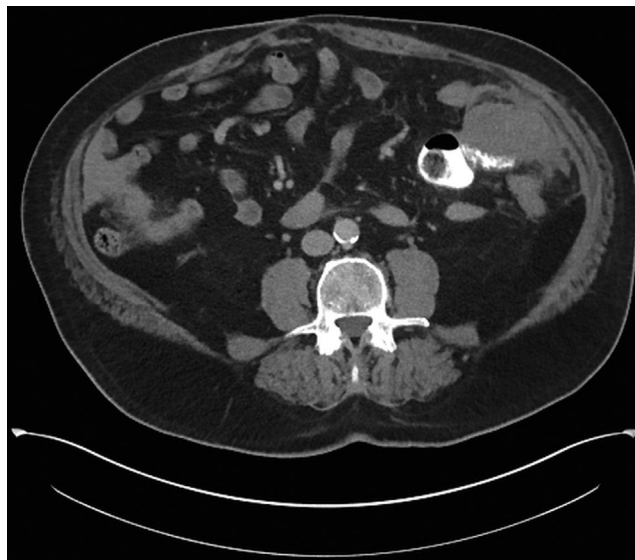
It is a repeat CT scan with contrast demonstrated a 7 cm segment of luminal narrowing in the proximal descending colon with adjacent resolving peri-colonic haematoma.
